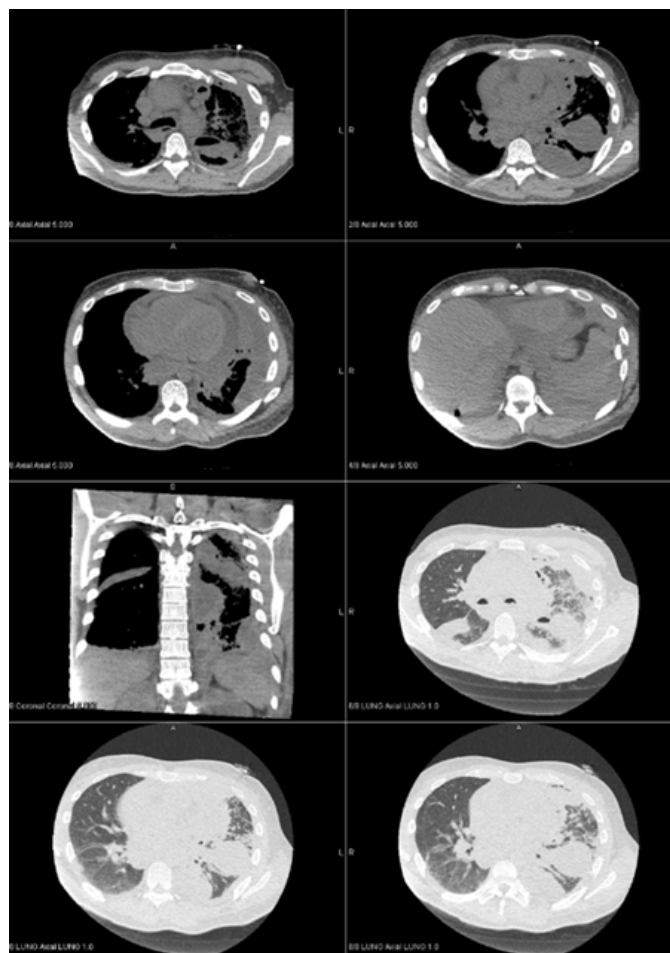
Computed tomography of chest without contrast on day five: Dense left lower lobe consolidation, slight improvement compared to prior CT chest imaging. Mild right base subsegmental consolidation. Two left chest tubes, interval decrease in the multiloculated left effusion, residual pleural thickening. Moderate right pleural effusion with interval increase.
